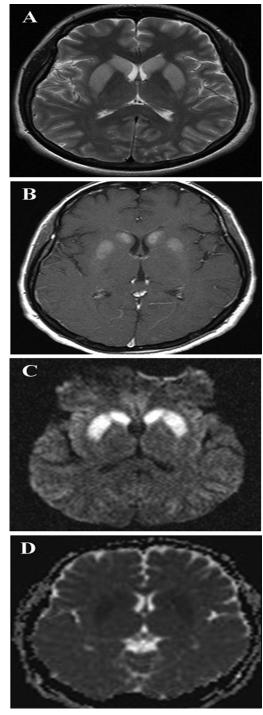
T2-weighted axial magnetic resonance imaging (A) demonstrates symmetric high signal intensities in the head of the caudate nucleus and putamen. These lesions are enhanced on T1weighted gadolinium-enhanced images (B). They are compatible with the cytotoxic edema observed in the diffusion-weighted sequences obtained 7 days after the event (C, D).
